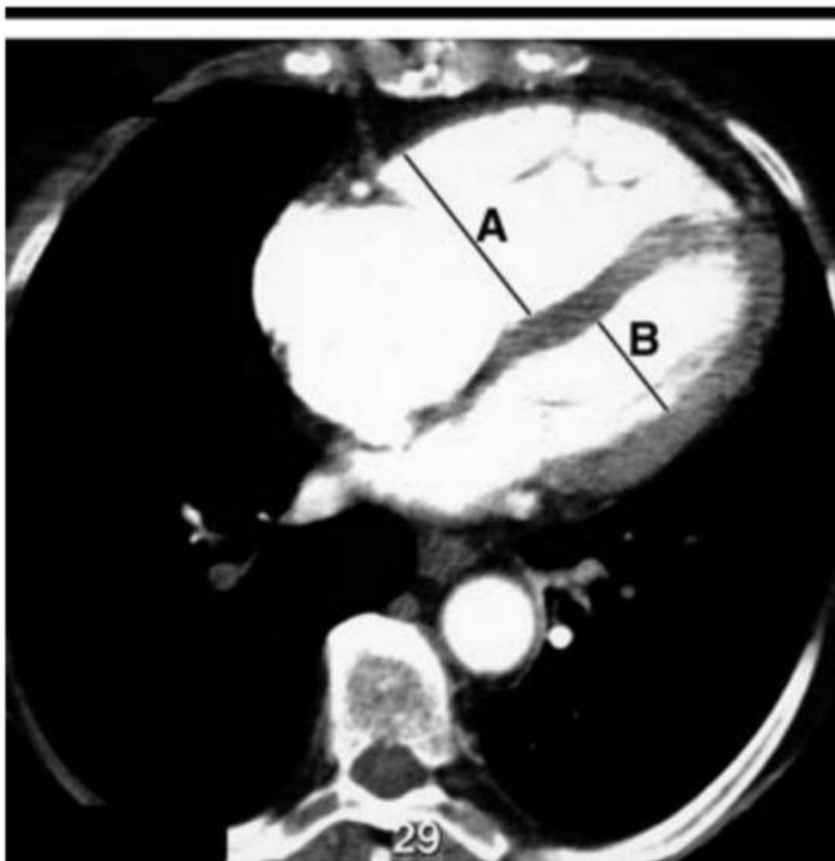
Transverse contrast-enhanced CT scan shows maximum minor axis measurements of the right ventricle (*A*) and left ventricle (*B*). Note the flattening of the interventricular septum. RV/LV ratio = 1.81.
